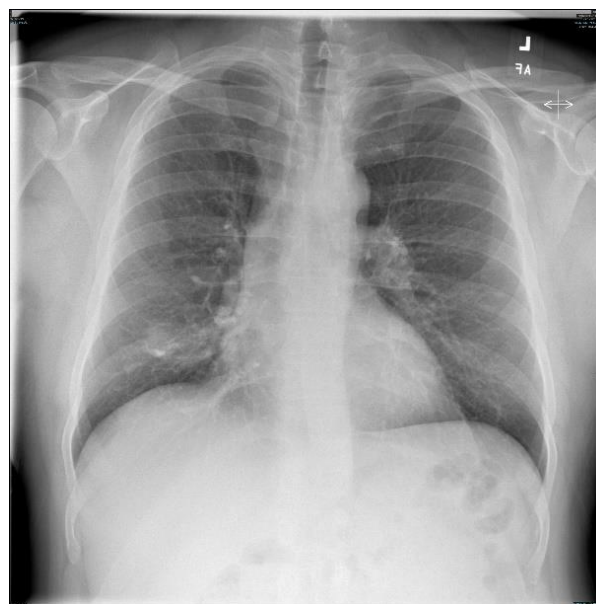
Chest X-ray, with a mild right middle lobe infiltrate.
